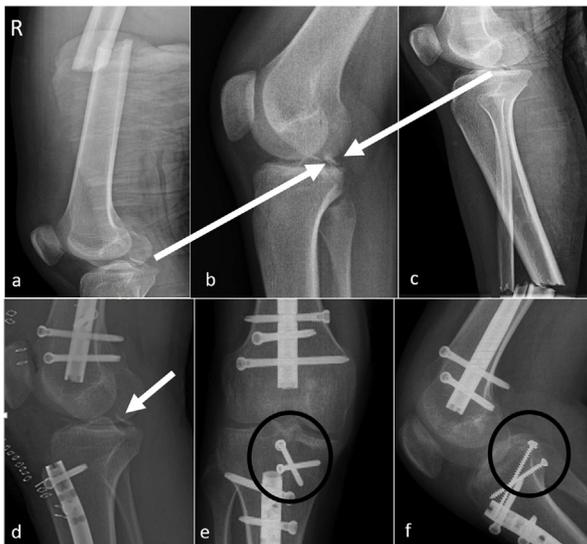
Case No. 12, R-Right, Knee Radiographs of a 19 year old boy who sustained a dashboard injury with a floating knee; the long bone fractures were acutely fixed and PCL injury was diagnosed and fixed after a month. Note the inconspicuous avulsion fragment (arrows). a–c Preoperative radiographs of the floating knee. d Radiograph at 10 days following tibia and femur nailing. e, f Knee Antero-posterior and Lateral view Radiographs at 3 months post PCL fixation showing a healed bony fragment (encircled).
